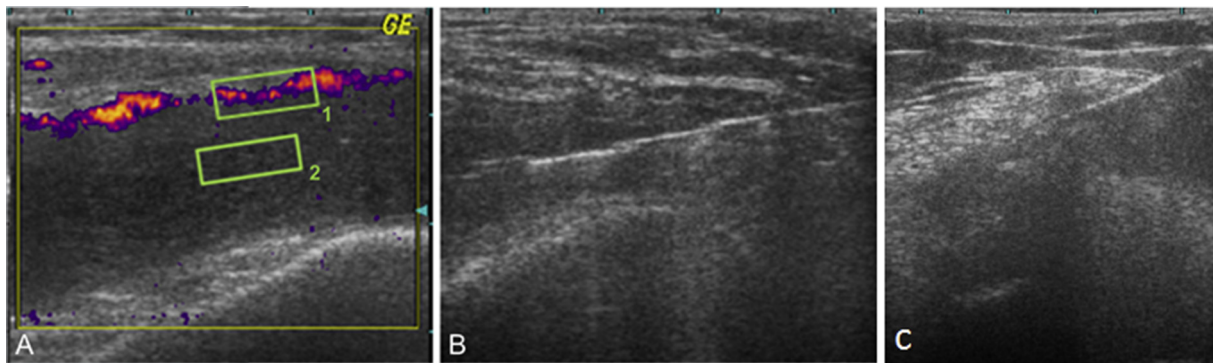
Power Doppler ultrasound of left knee joint in a 30-year-old woman with rheumatoid arthritis. (A) Transverse scan at the suprapatellar area revealed prominent synovial hypertrophy. Presence of power Doppler signals at the basal layer of synovium (block 1). Otherwise, no synovial power Doppler signal elsewhere (block 2). (B) Ultrasound-guided biopsy of synovium in the block 2 area. (C) Ultrasound-guided biopsy of synovium in the block 1 area.
